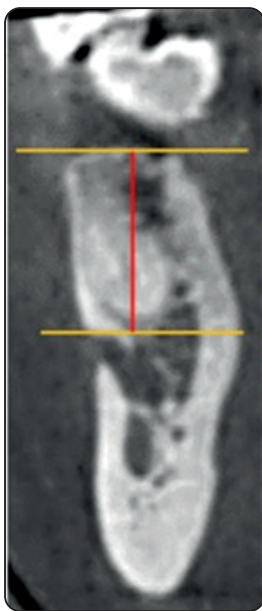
CBCT, cross-sectional view showing the distance between the alveolar crest (AC) and the upper border of the mental foramen (MF).
